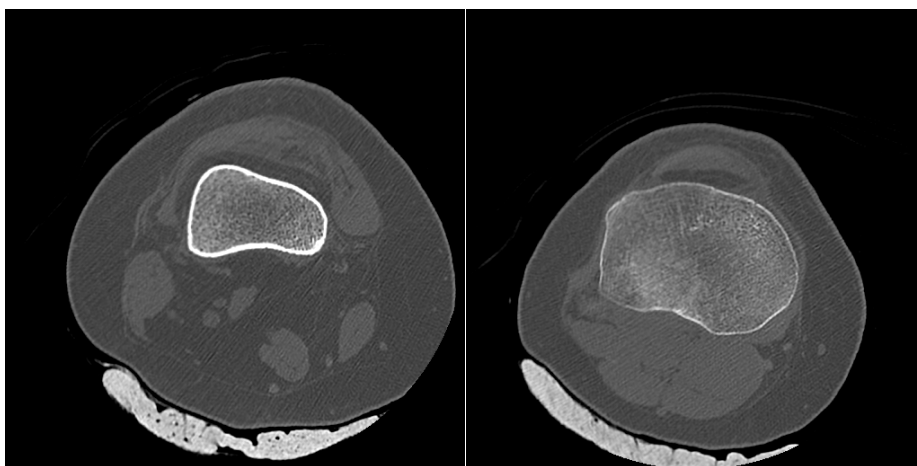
Two CT images belonging to the same patient dataset. The intensity values of the cortical zone are different in the diaphysis (left) and the epiphysis (right). The cortical area is much thinner in the epiphysis (right).
